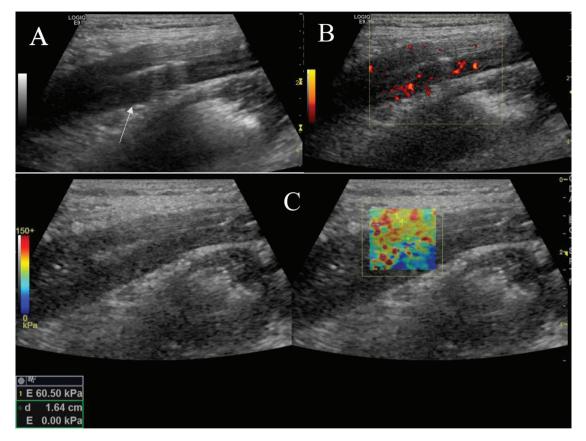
US image of a 22-year-old man with active ulcerative colitis. (A) US image of the rectosigmoid colon with a thickened bowel wall and loss of haustral markings (arrow). (B) Color Doppler US image of the rectosigmoid colon showing Doppler signals in both the intestinal wall and the surrounding mesenteric fat (Limberg score: Grade 3). (C) SWE measurements of the rectosigmoid colon were obtained using a circular ROI placed on the bowel wall. The 2D-SWE map (right side) and grayscale image (left side) are shown. (US: Ultrasonography, SWE: Shear wave elastography).
